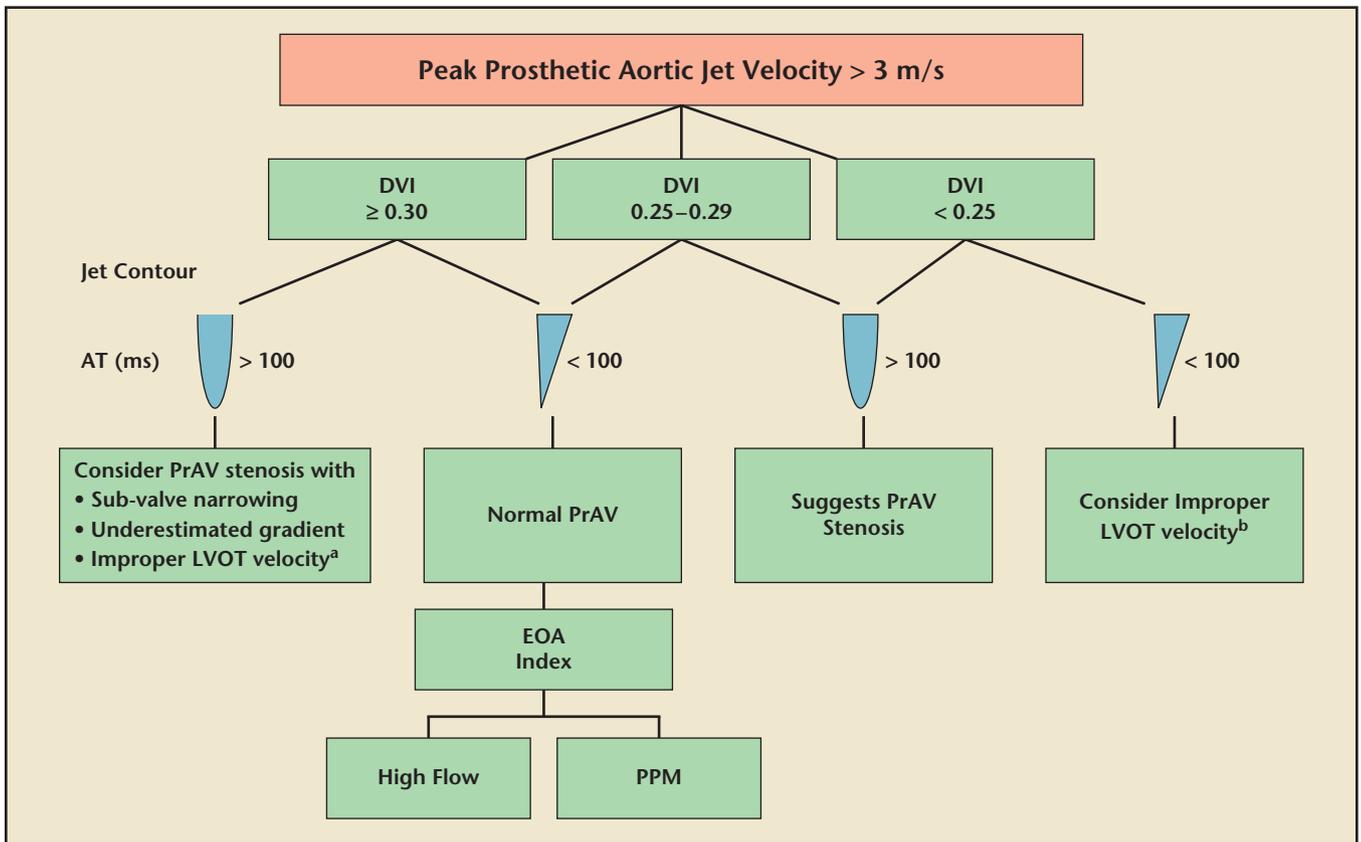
Algorithm for evaluation of elevated peak prosthetic aortic jet velocity incorporating DVI, jet contour, and AT. ^aWhen the pulsed-wave Doppler sample in the LVOT is too close to the aortic valve V₁ will be elevated and lead to erroneous results (particularly when jet velocity by continuous-wave Doppler is ≥ 4 m/s). ^bWhen the pulsed-wave Doppler sample in the LVOT is too far away from the valve (too apical) inaccurate assessment of the aortic valve stenosis can also occur (particularly when jet velocity is 3-3.9 m/s). Stenosis further substantiated by EOA derivation compared with reference values if valve type and size are known. Fluoroscopy and TEE are helpful for further assessment, particularly in bileaflet valves. AT, acceleration time; AVR, aortic valve replacement; DVI, dimensionless valve index; EOA, effective orifice area; LVOT, left ventricular outflow tract; PPM, patient-prosthesis mismatch; PrAV, prosthetic aortic valve; TEE, transesophageal echocardiography. Reprinted with permission from Zoghbi WA et al.⁷
